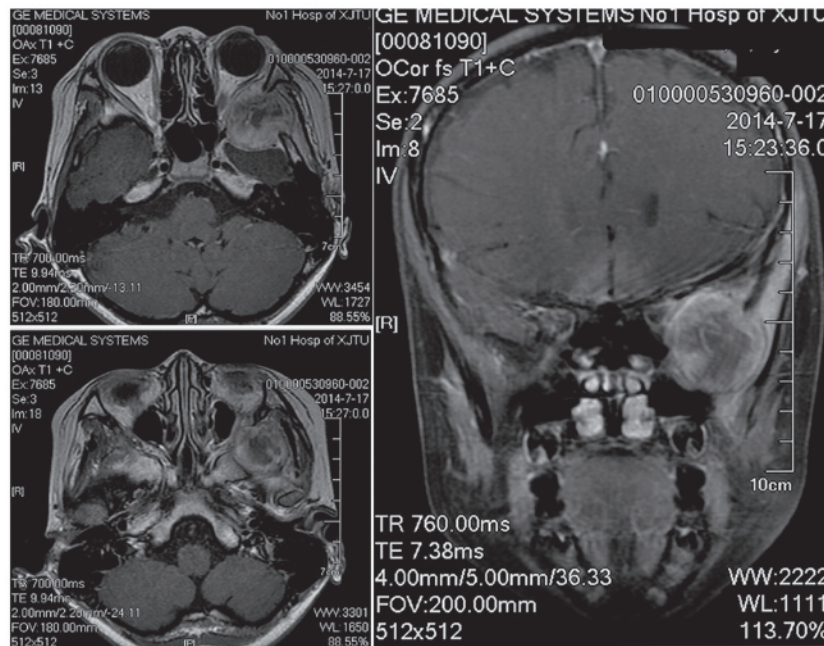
Magnetic resonance imaging revealed a heterogeneously contrast-enhancing mass near the left temporal pole, which eroded into the left orbit and maxillary sinus.
